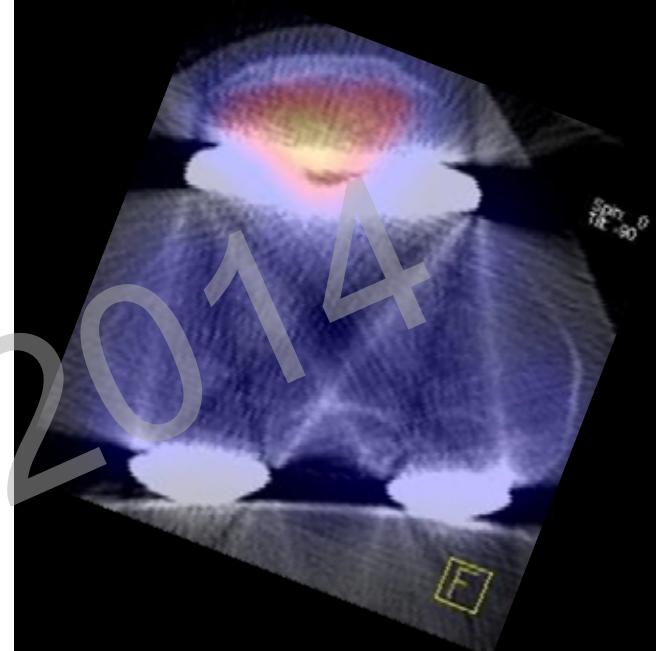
The previously published and used SPECT/CT classification system. (Reprint permission from Journal KSSTA, Springer).
